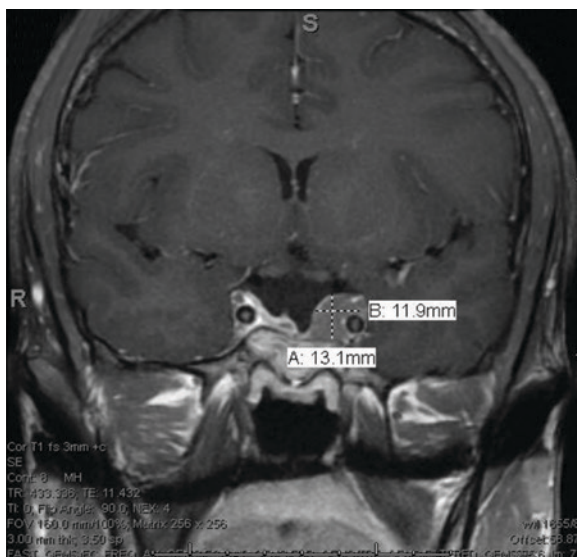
MRI after the first operation at the outside hospital, showing residual tumor encasing the left internal carotid artery by approximately 180 degrees.
